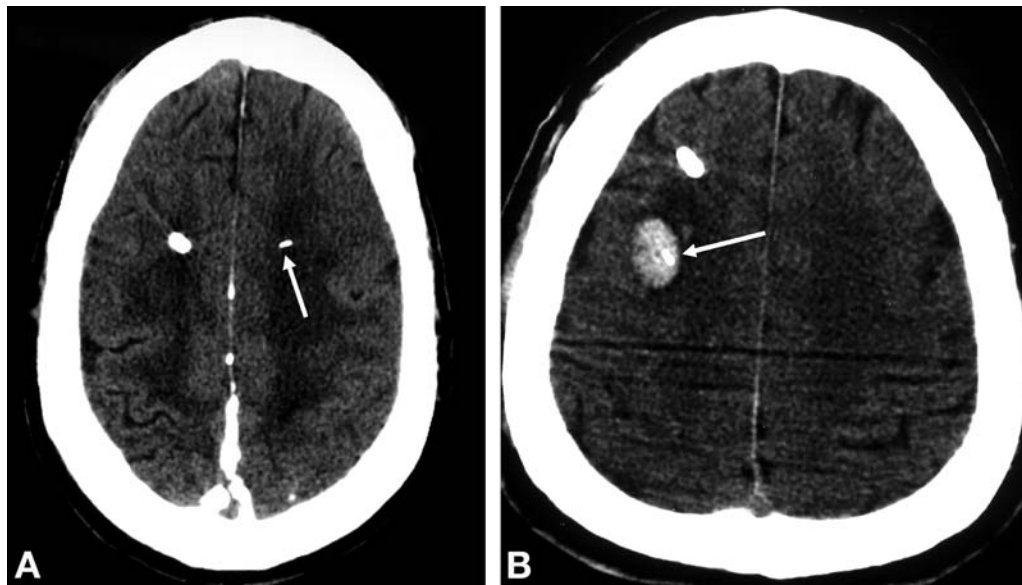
Noncontrast CT scans demonstrating brain tissue oxygen probe tip location. Patient 1 (A) had a functional oxygen probe with the tip located in white matter ipsilateral to a thalamic hemorrhage. Patient 7 (B) had a nonfunctional oxygen probe because the tip was located in a hematoma that resulted from an insertion drill bit. The hematoma was clinically asymptomatic. The white arrows in A and B indicate the oxygen probe tips. The larger hyperdensities are ventriculostomy catheters.
